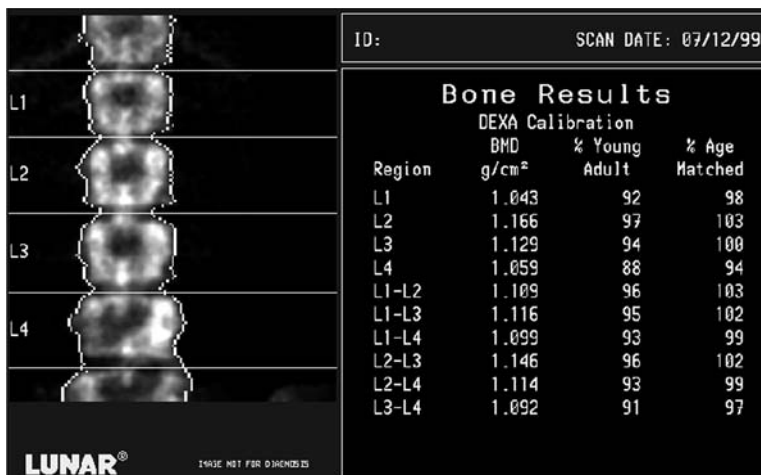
A DXA PA spine study acquired on the Lunar DPX. The image is unusual at L4, with what appears to be an absence of part of the posterior elements. This was confirmed with plain films. This should decrease the BMD at L4.
